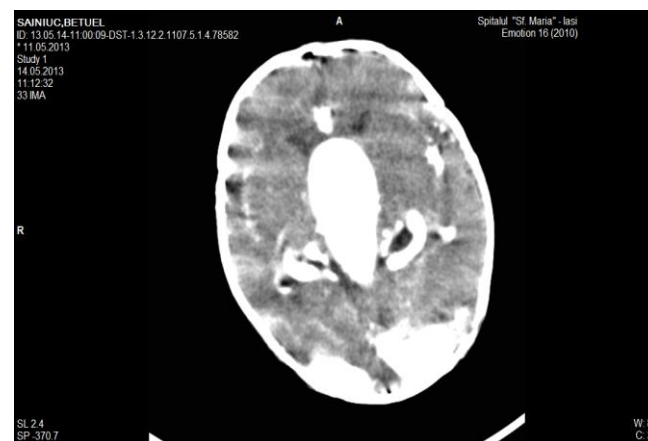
Cerebral CT with contrast - Aneurysm of Galen vein.
